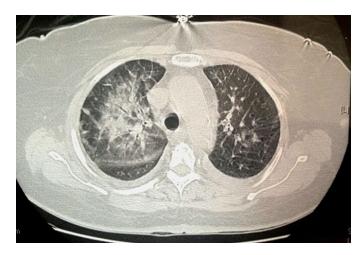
Thoracic computed tomography showing a focal point of right alveolar condensation.
